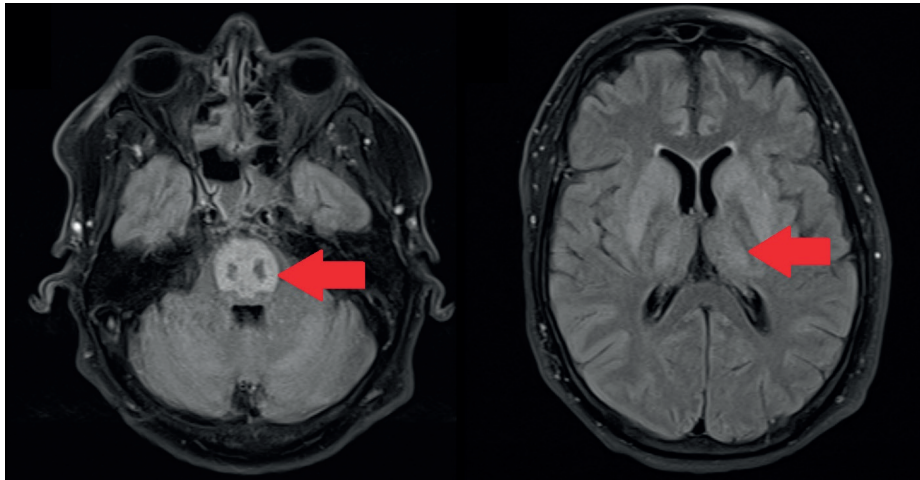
Axial T2-weighted FLAIR magnetic resonance brain scan images showing signal change (broad red arrows) with restricted diffusion around the central pons (but sparing the pontine cortical spinal tracts) and involving both thalami and basal ganglia around the posterior limb of the internal capsule bilaterally.
